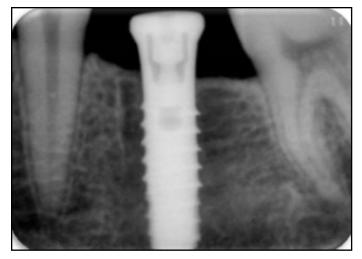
Baseline radiograph.
